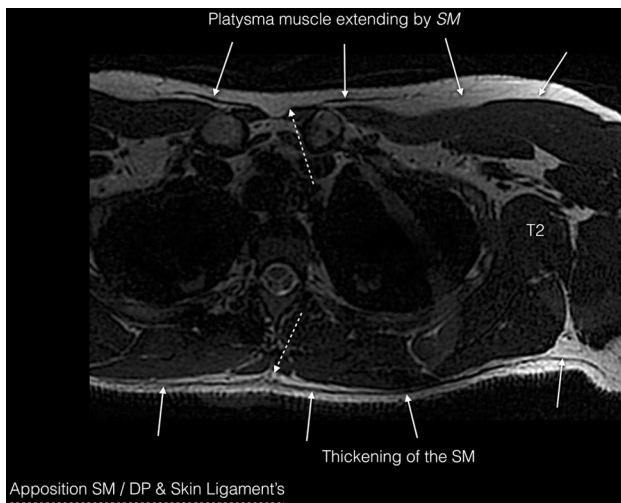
MRI scan in axial plane of subject #2 at the level of the upper part of the thorax. Anteriorly, the platysma is in continuity with the SM. Posteriorly, the SM is found to be thickened. Laterally, the RCN density gradually increases
